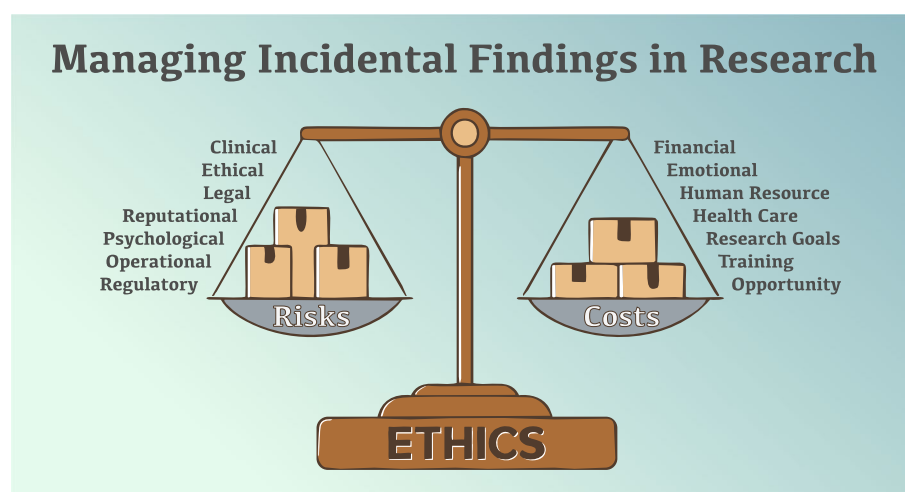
Managing incidental findings in PET/CT imaging research is a balancing act of risks and costs, approached from an ethics and duty of care perspective
